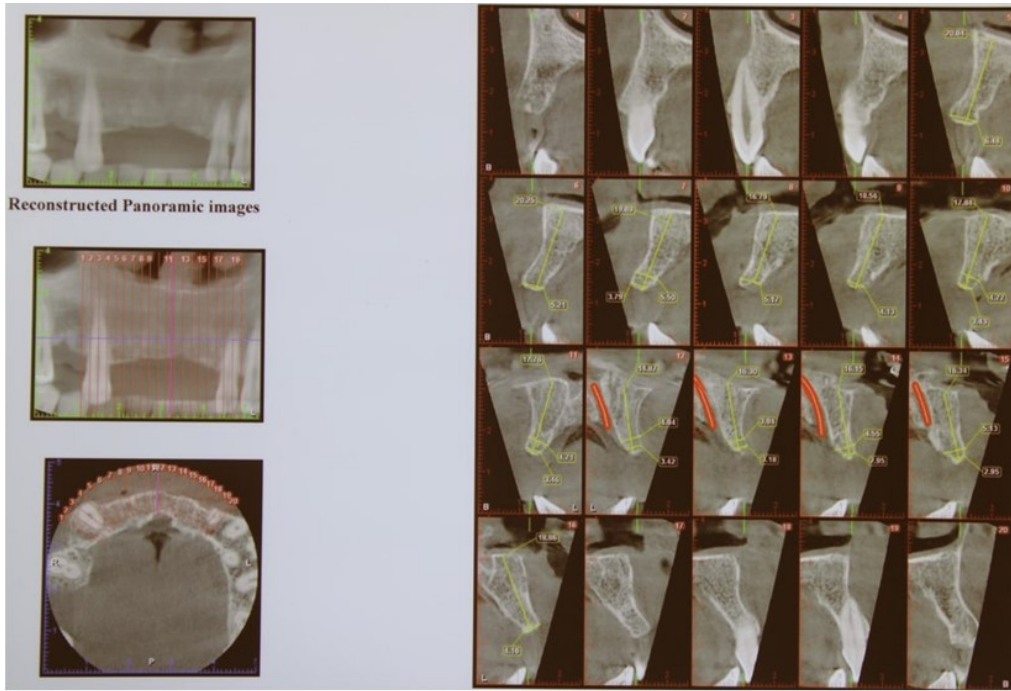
Radiographic evaluation for implant placement
